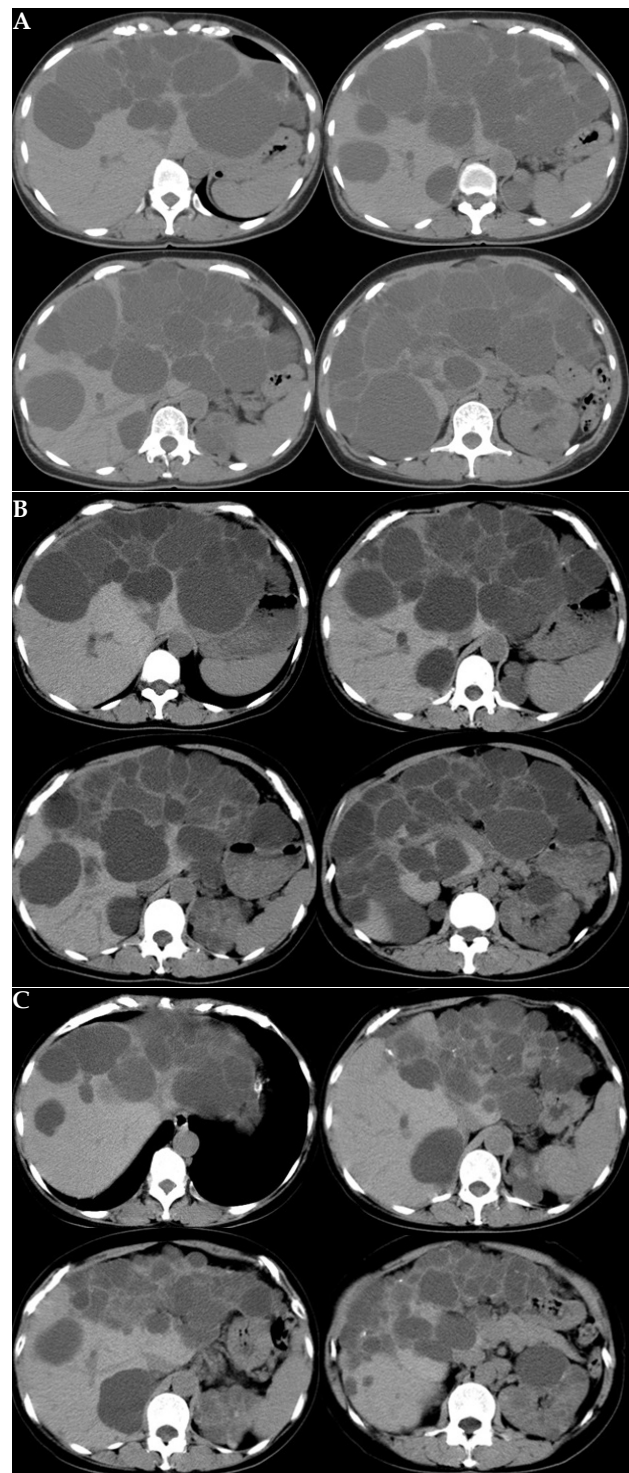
Computed tomography (A) before treatment; (B) 72 months after first treatments; and (C) 150 months after first treatments.
